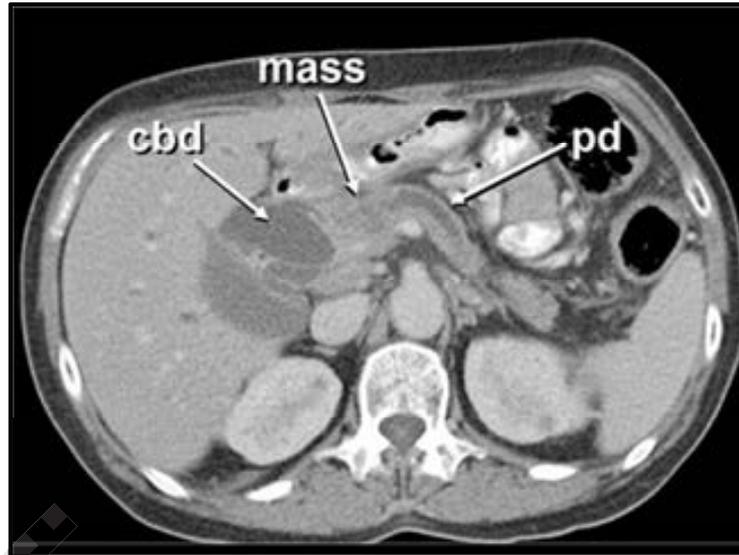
CT image of cancer head of pancreas.⁽⁵⁸⁾
